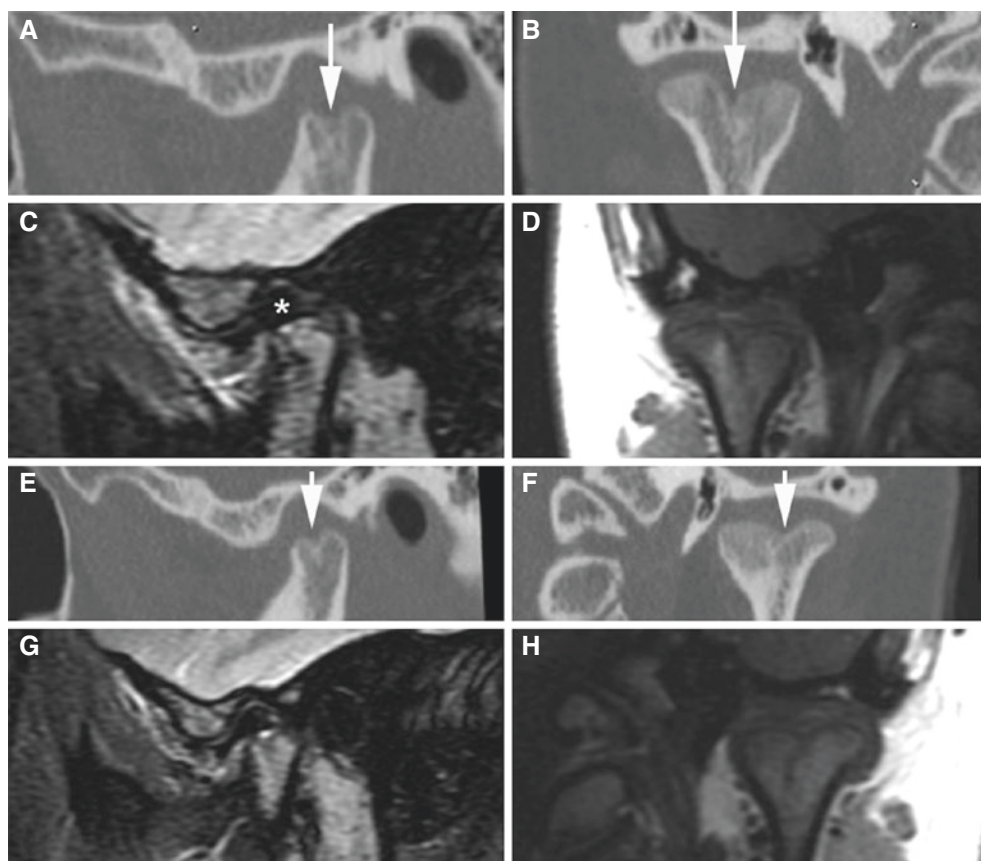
Bifid condyle, bilateral; 18-year-old female. (A) Oblique sagittal and (B) oblique coronal CT images of the right joint show bifid condyle (*arrow*). (C) Oblique sagittal STIR MRI and (D) oblique coronal T1-weighted MRI confirm bifidity and additionally show normal disc with posterior band superior to the condyle (*asterisk*). (E) Oblique sagittal and (F) oblique coronal CT images of the left joint show bifid condyle (*arrow*). (G, H) MR images corresponding to those in (C) and (D) confirm bifidity and additionally show normal disc
